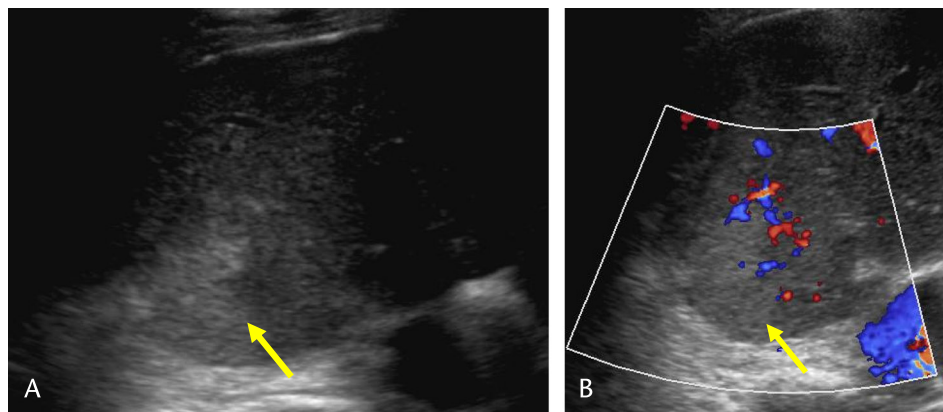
Transverse gray-scale (A) and color Doppler (B) images of the right kidney demonstrate a wedge-shaped hyperechoic region with decreased perfusion on color Doppler US.
